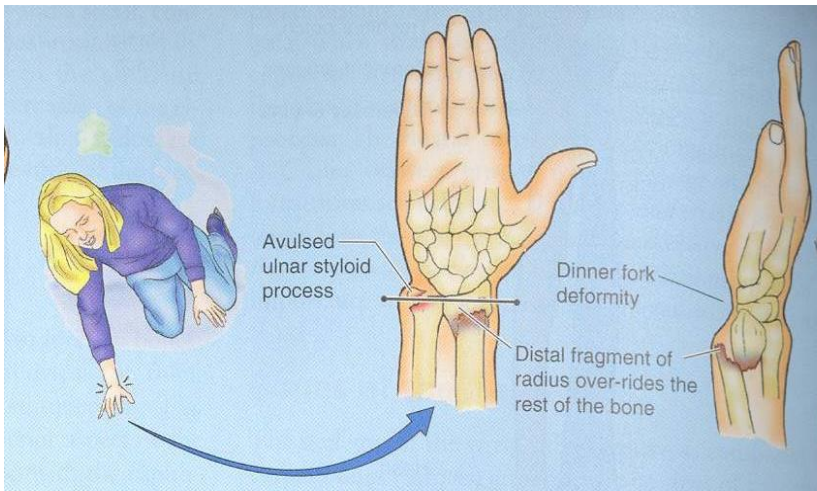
(a) Scaphoid fracture (arrow). (b) Colles' fracture showing 'dinner fork' deformity. (c) Colles' fracture, X-ray.
